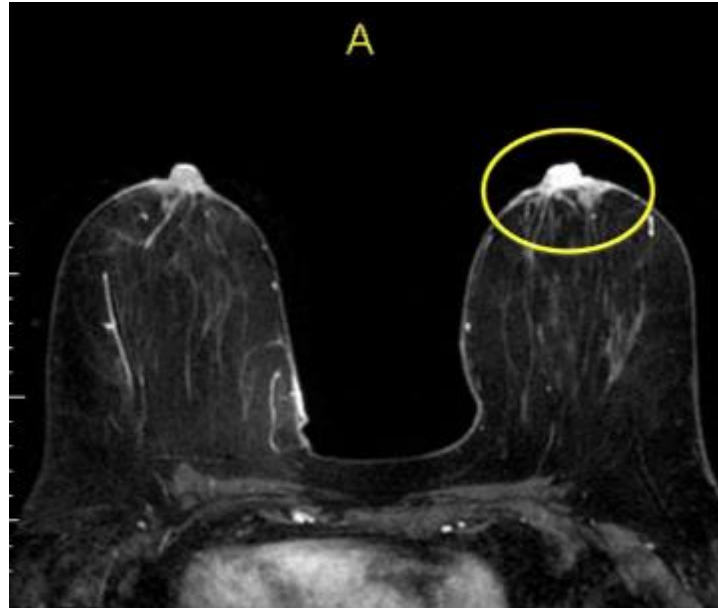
MRI imaging showing thickening of NAC with no underlying lesions
